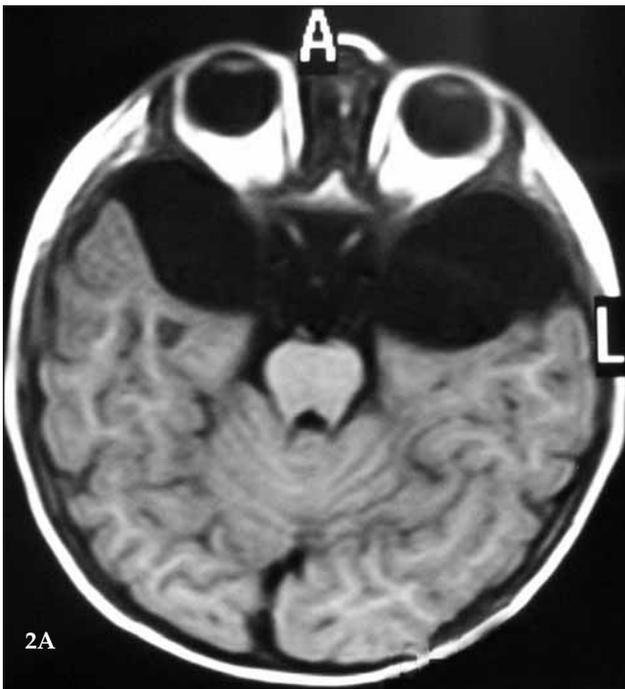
Axial T1-weighted (A) and coronal (B) T2-weighted MRI demonstrating bilateral arachnoid cysts.
